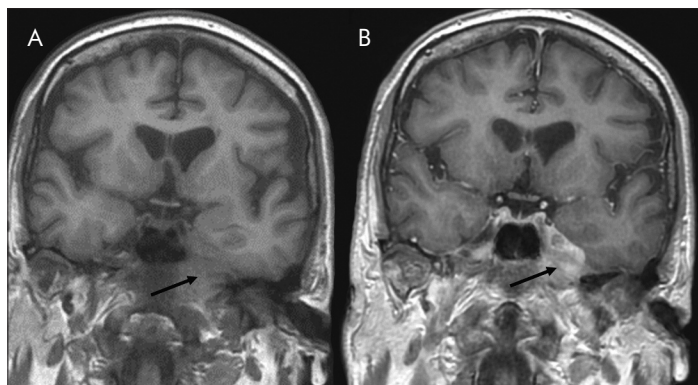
Comparing the native (A) and gadolinium-enhanced (B) T1-weighted magnetic resonance image (MRI) scans, contrast enhancement is showed at the apex of the left petrous bone (black arrows)
